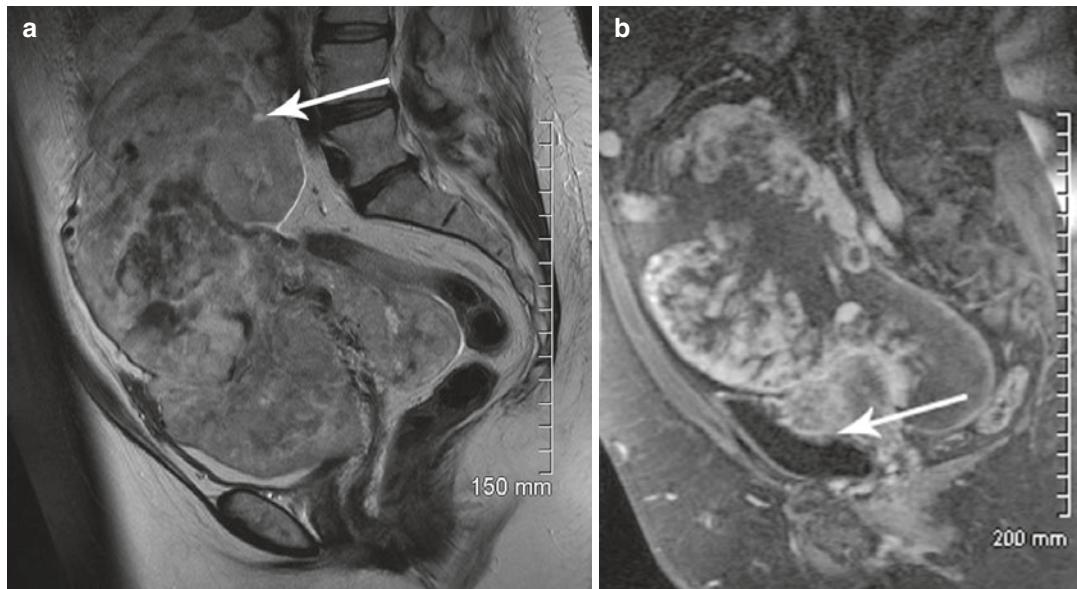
(a) Sagittal T2-weighted MR image of a 57-year-old woman with uterine sarcoma mimicking a large fibroid (arrow). Imaging done 10 years before demonstrated a normal uterus without any mass or fibroid (not
